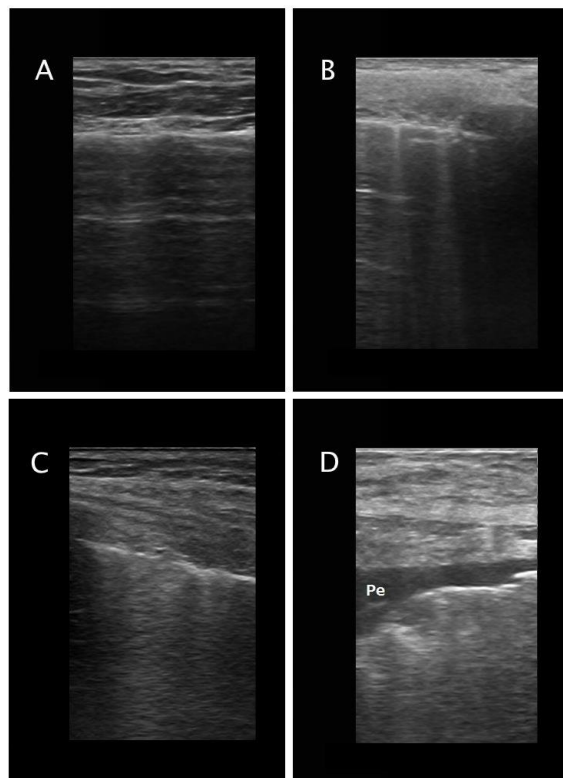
Lung ultrasound patterns corresponding to progressive loss of aeration
